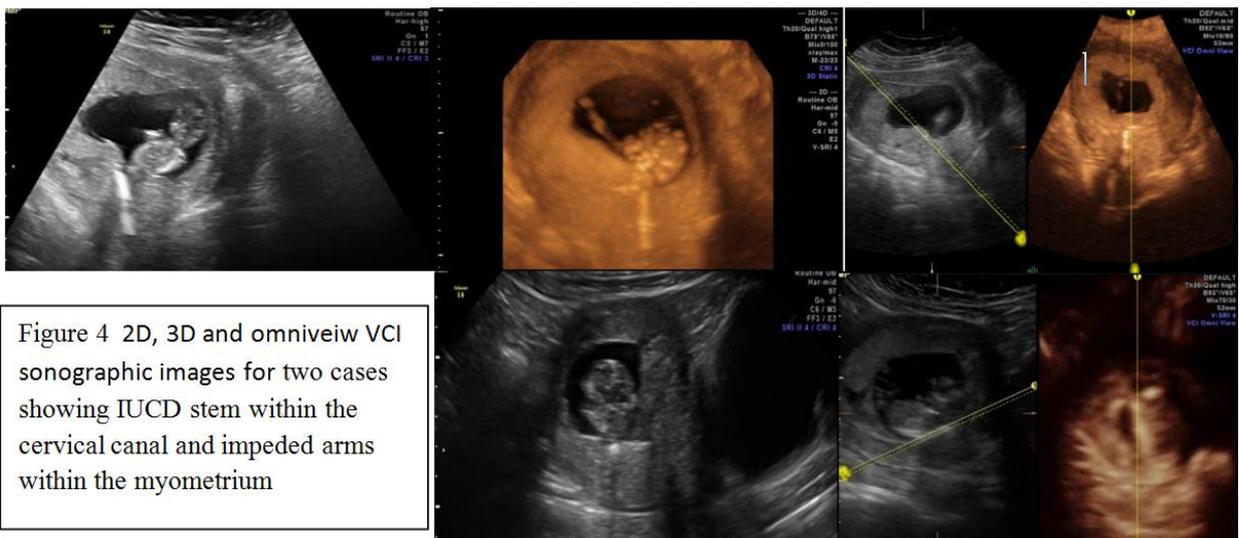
2D, 3D and omniview VCI sonographic images for two cases showing IUCD stem within the cervical canal and impeded arms within the myometrium
